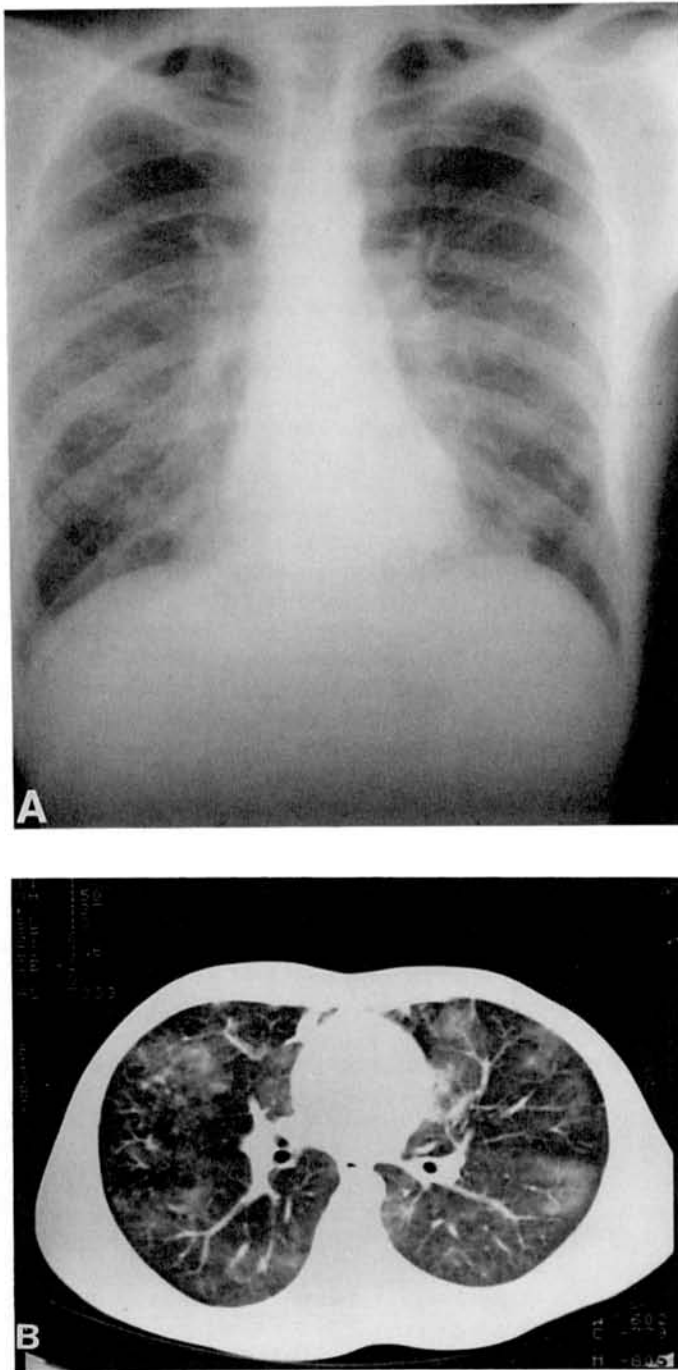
(A) Chest roentgenogram, and (B) chest CT scan of a 28-year-old-male patient who presented, 7 months postallogeneic bone marrow transplantation for acute myeloid leukemia, with a respiratory illness associated with a moderate-to-severe fall in lung volumes and moderate fall in the pulmonary diffusing capacity (TLCO). The diffuse interstitial process noted on chest roentgenogram was confirmed on CT scan. Rapid resolution of all abnormalities occurred following treatment with prednisolone.
